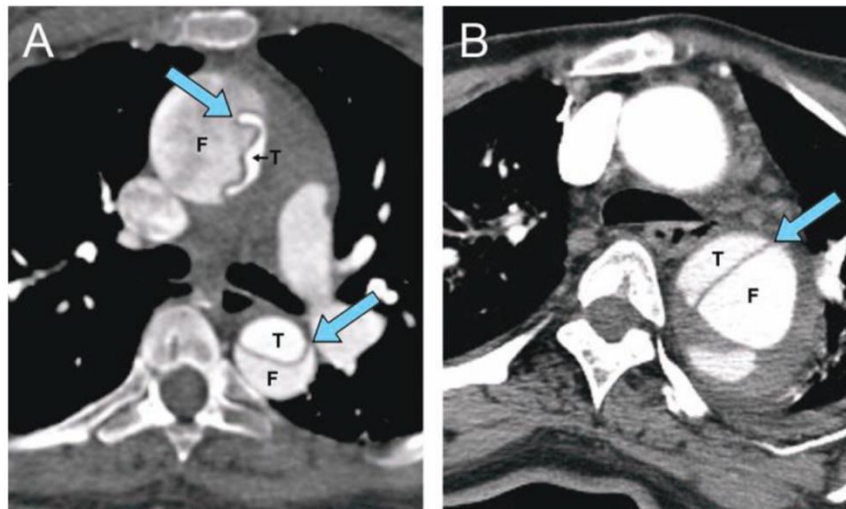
Computed tomographic scans showing that the aorta has been separated into two channels—the true (T) and false (F) lumens—in two patients with different phases of aortic dissection. A. An acute DeBakey type I aortic dissection. The dissecting membrane appears wavy (arrows) in the early phase of dissection. Here, the true lumen of the proximal aorta can be seen to be extensively compressed. This may lead to malperfusion of the heart. B. A chronic DeBakey type III aortic dissection. In the chronic phase, the membrane appears straighter and less mobile (arrow) because it has stabilized over time.
